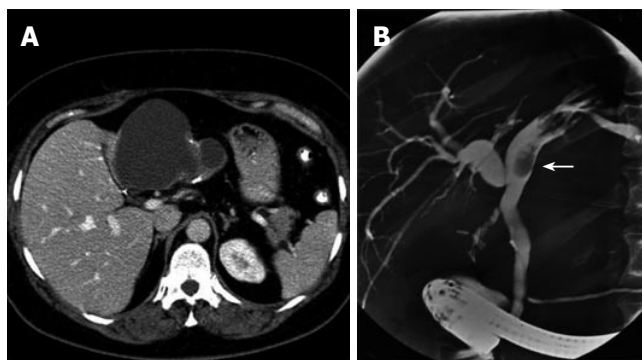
Abdominal CT-scan showing a large cystic mass in the left liver lobe with internal septations and calcifications in the cyst wall (A) and ERCP showing a polypoid lesion in the left hepatic duct (arrow) in case 1 (B).
